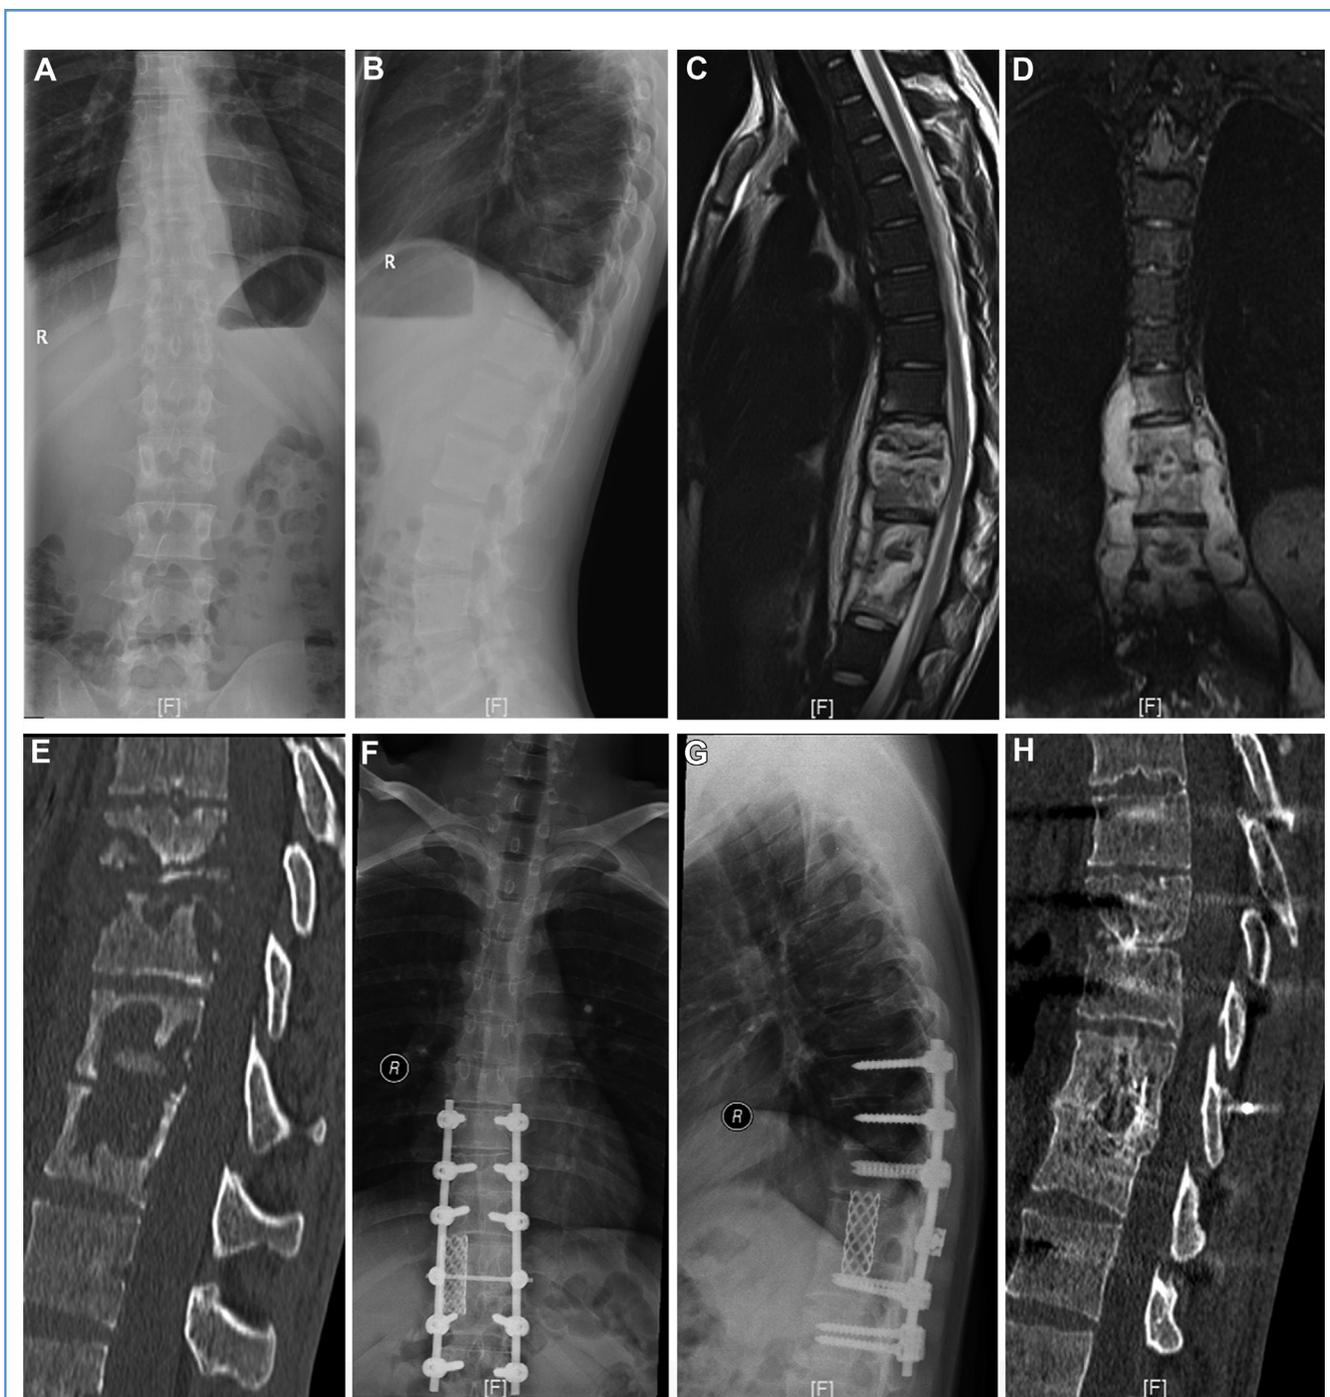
Preoperative (A and B) radiography, (C and D) magnetic resonance imaging, and (E) computed tomography (CT) of a 24-year-old male patient with tuberculosis at T8–T12 with extensive paravertebral abscesses. (F
